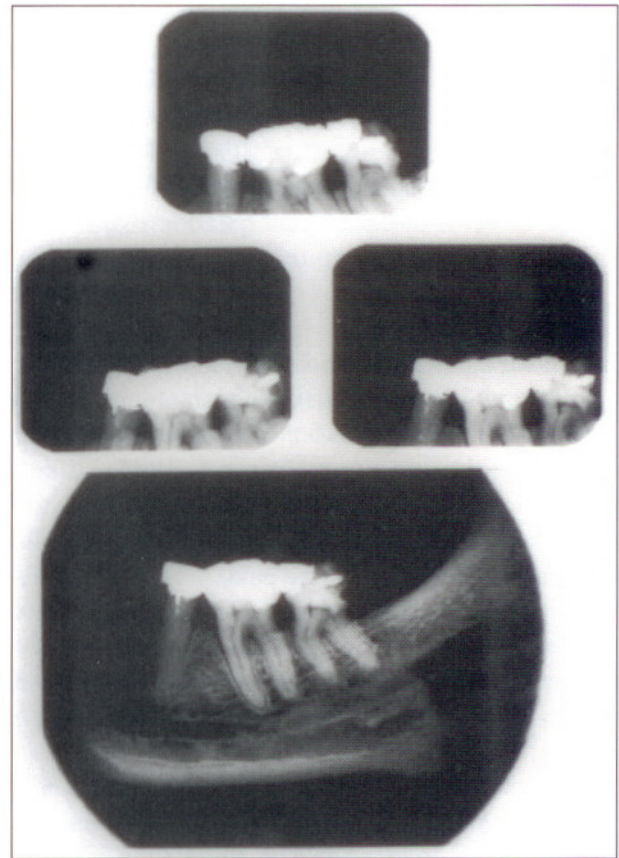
Radiographs taken at an angle to duplicate optimal characteristics of a bitewing radiograph (top) and additional exposures with vertical (left) and horizontal tube shifts (right) to duplicate likely errors during antemortem radiography. Bottom radiograph is a reference to Fig. 1
